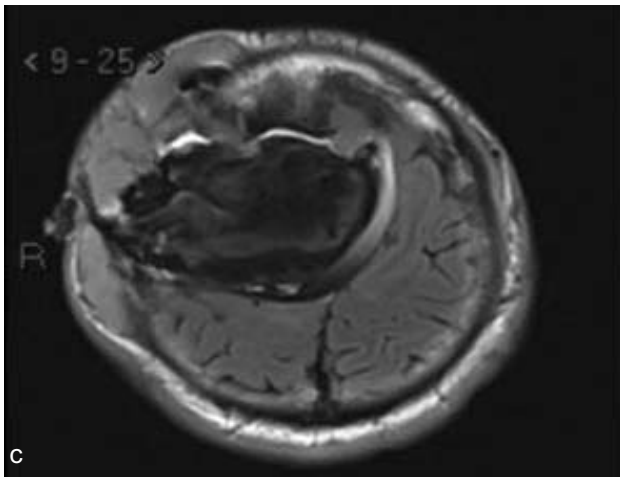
Magnetic resonance Imaging. A: Coronal T1 weighted image: Iso to hypointense peripheral nodular mass with significant mass effect upon underlying brain parenchyma. B: Axial T2 weighted image heterogeneous nodular peripheral masses at surgical bed. C: FLAIR images with iso to hyperintense nodular masses in surgical bed on right side. D: DWI images with patchy restriction in nodular masses on right side. E: Coronal post contrast T1WI, heterogeneous enhancement in lesions peripherally located, suggesting tumor growth.
